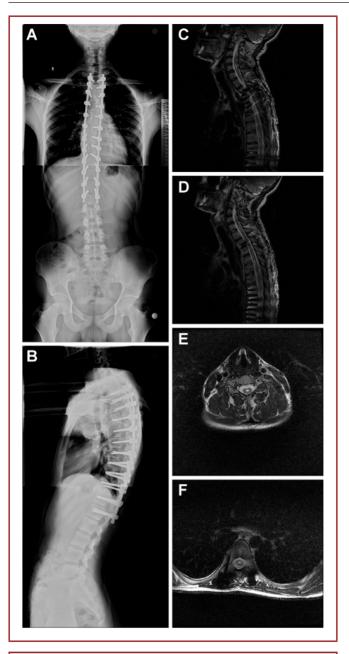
(A-B) Preoperative AP X-ray film indicating double thoracic scoliosis curvature (Cobb angle; 40° and 42°), Cobb angle on lateral graphy is 62°. (C-F) MRI showed extensive syringomyelia in CM-I and cervical and thoracic region (Syrinx level is between C4 and D9, Syrinx Width is 5 mm at C6 level and 7 mm at T6 level).
